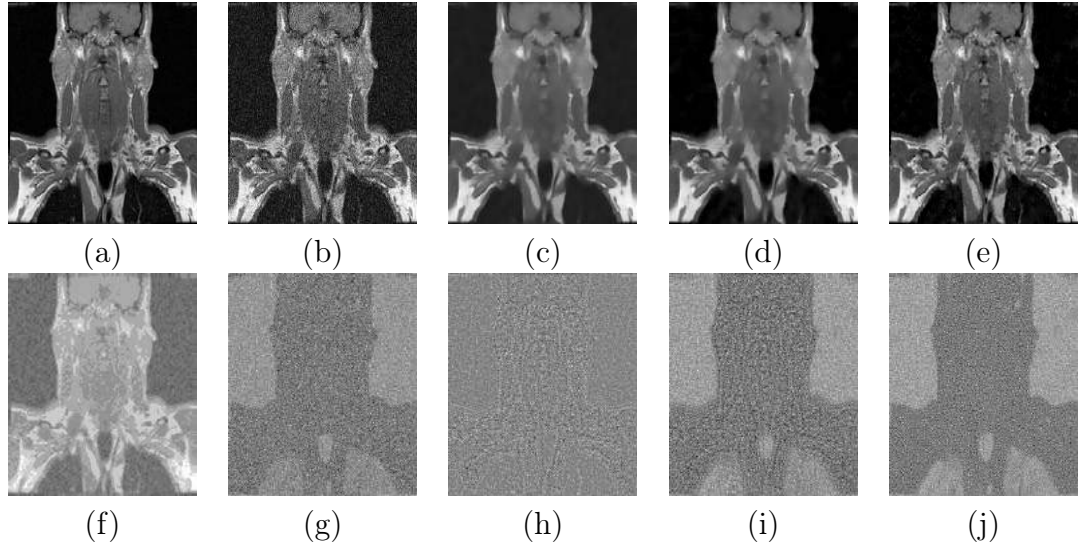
Real MR image 1: (a) Noise-free image, (b) noisy image (noise level = 9%), (c) NLM-output [46], (d) UNLM-output [42], (e) PCNNNI_IUNLM output, (f) Time Matrix, (g) actual noise, (h) residual of NLM, (i) residual of UNLM, (j) residual of PCNNNI_IUNLM.
